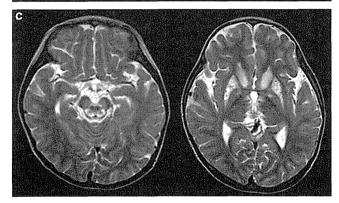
Magnetic resonance imaging findings in (a) Patient 1, (b) Patient 2 and (c) Patient 3. Axial T2-weighted images (TR 4600, TE 100) show high signal intensity areas in the bilateral putamen and caudate nucleus of Patient 1 (a), bilateral putamen, left globus pallidus, caudate nucleus and thalamus of Patient 2 (b), and bilateral putamen, caudate nucleus, globus pallidus and brainstem of Patient 3 (c).
